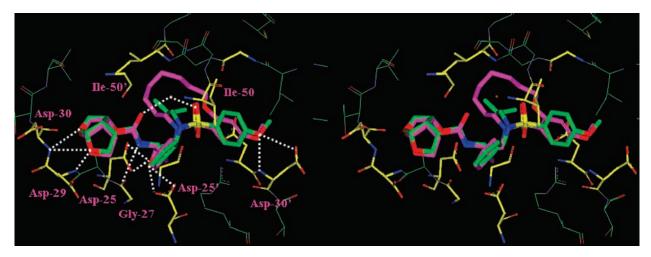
An overlay of energy-minimized macrocyclic inhibitor 15c (magenta) with the X-ray structure of inhibitor 2 (green)-bound HIV-1 protease.
